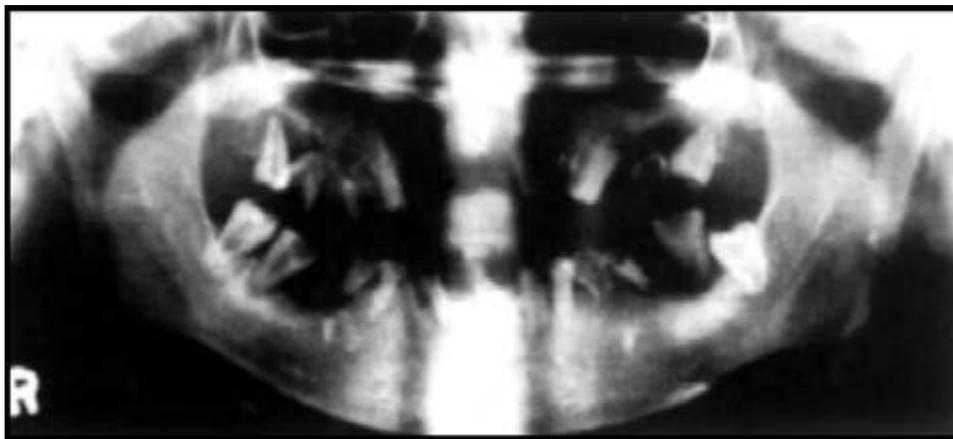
Orthopantomogram of a case with ectodermal dysplasia
